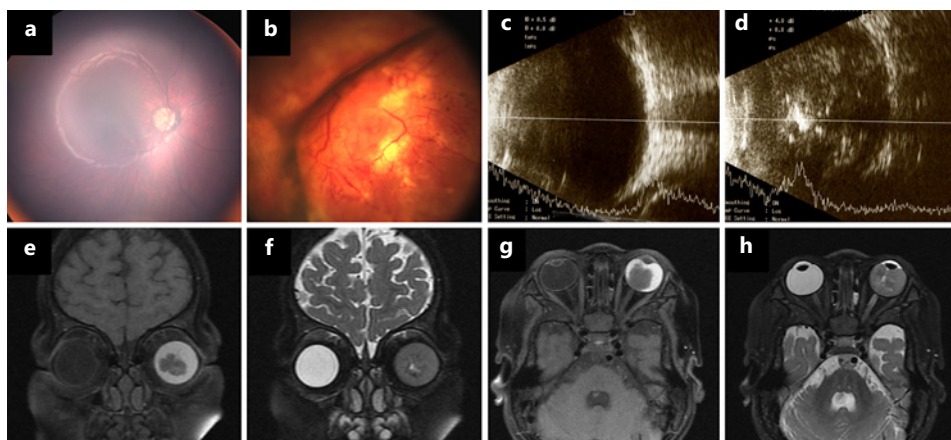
Unilateral retinoblastoma in the left eye. Fundus photo: a right eye, b left eye; ultrasonography: c right eye, d left eye; e coronal T1 magnetic resonance imaging (MRI); f coronal T2 MRI; g axial T1 MRI; and h axial T2 MRI.
